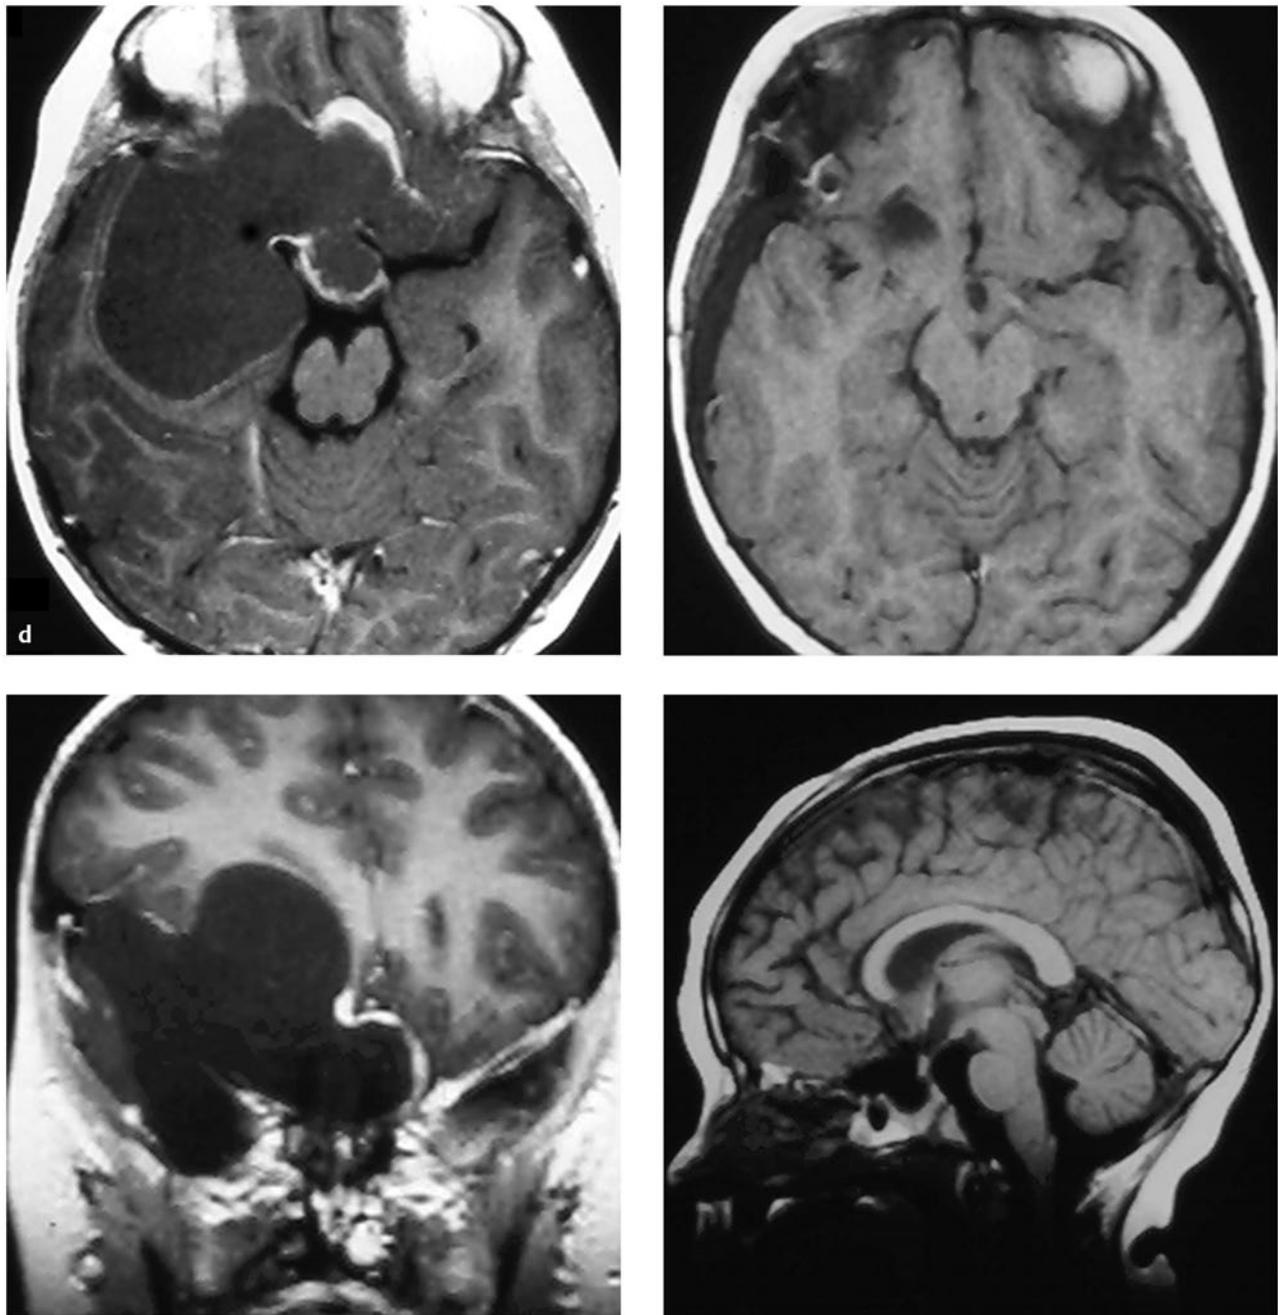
(continued) (d) Pre- and postoperative MR images of a giant (7 cm) craniopharyngioma.
